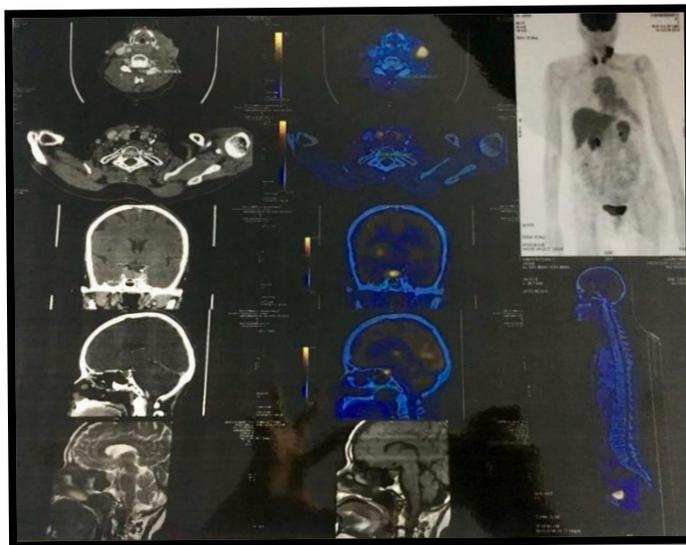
FDG-PET scan Figure 2- Marking of lesion
